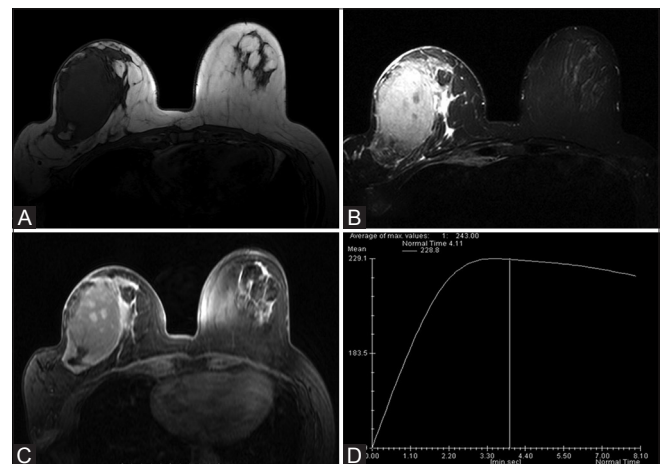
(A-D): MRI of breast showing a well-defined, smoothly marginated mass in right breast iso- to hypointense on T1W (A) and hyperintense on STIR with few hypointense nodules (B). On dynamic contrast study, the lesion shows heterogeneous enhancement (C) with plateau and slow washout of contrast in time-intensity curve (D)
